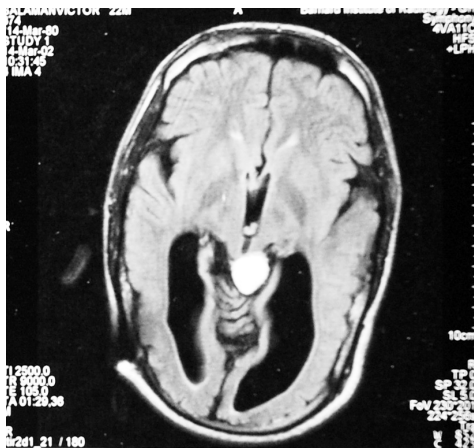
Hamartoma of the tuber cinereum (1) - CT film.
